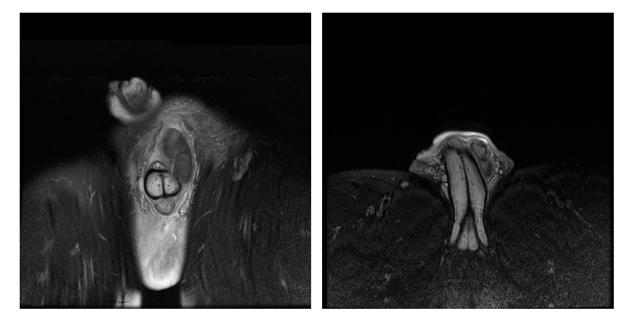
MRI Finding of Penile Fracture. Adapted from Ory *et al.* [15]. Copyright CUA. Reprinted with permission. 5 mm defect of left tunica albuginea and overlying hematoma on 1.5T MRI imaging.
